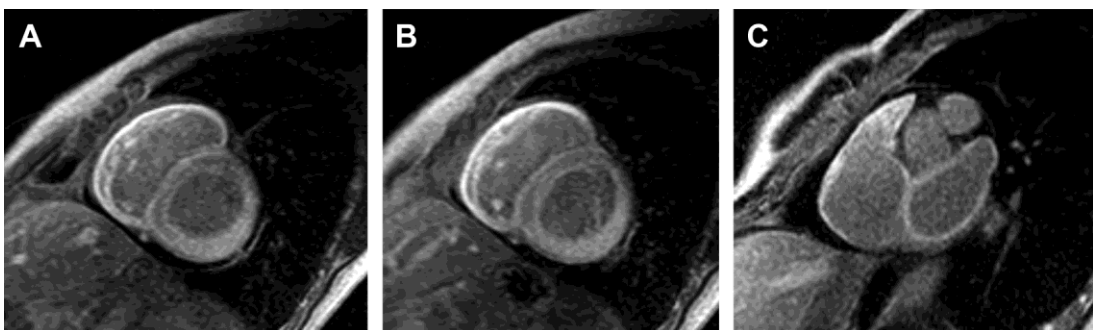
Short axis late gadolinium enhancement MR images in a patient with cardiac amyloidosis. Midventricular short axis images (A, B) reveal marked diffuse enhancement of the right ventricular free wall as well as patchy near transmural enhancement of the lateral and inferior left ventricular walls. Short axis image through the atria (C) demonstrates diffuse enhancement and mild thickening of right and left atrial walls.
